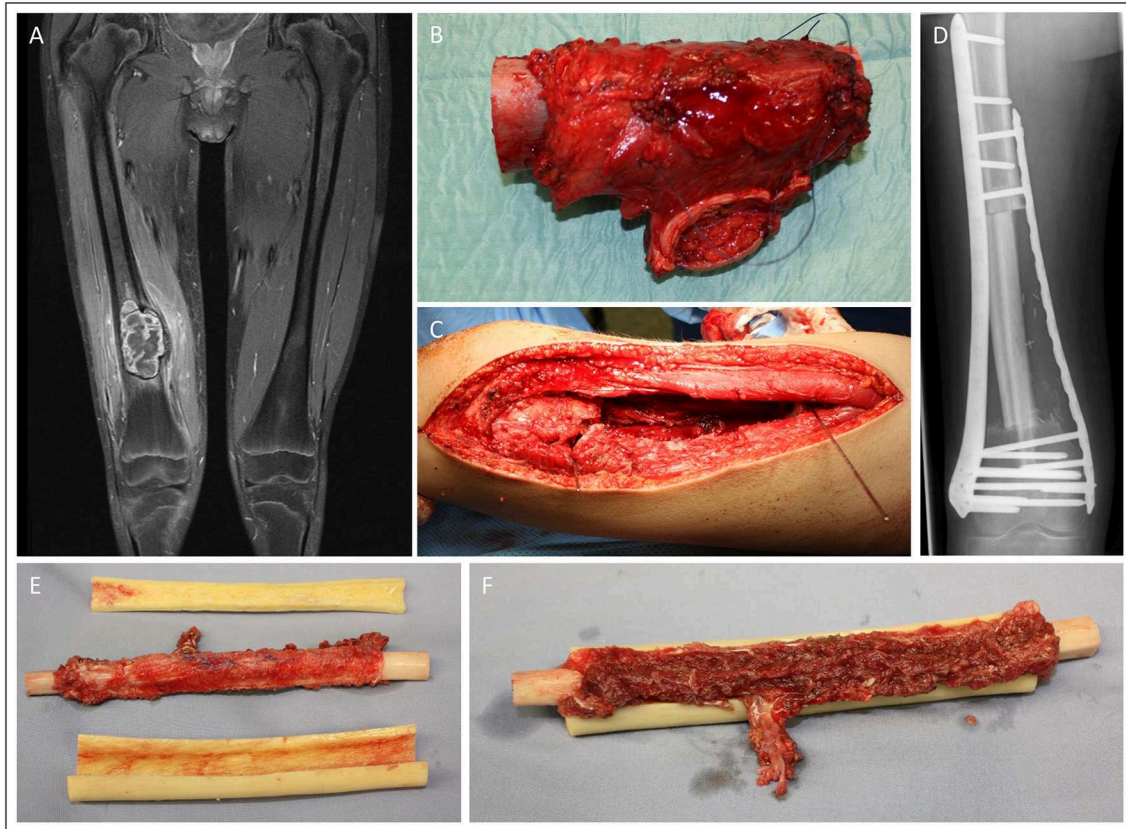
Fifteen-year old male patient presenting with osteosarcoma in the distal femur. Femoral reconstruction was performed with a free fibula graft combined in an allograft as described by Capanna. Pre-OP MRI presentation of the sarcoma mass in the distal femur (A). Intraoperative images of the resected tumor (13 cm length) (B) and the resulting femoral defect (C). X-ray of the result in the 2 month follow-up (D). (E) and (F) demonstrate the intraoperative preparation of the microvascular free fibular autograft supported by a peripheral massive allograft shell.
